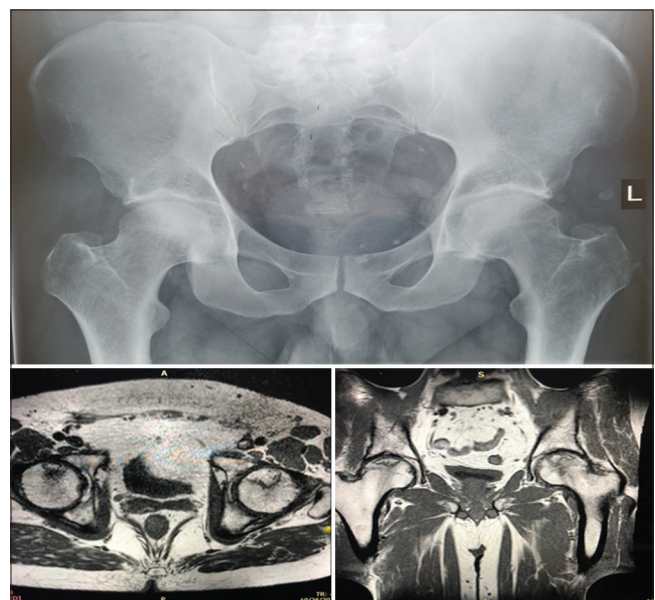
Anteroposterior radiograph and MRI of the 50-year-old male patient confirming bilateral avascular necrosis of the femoral head (Ficat–Arlet stage I/II)
